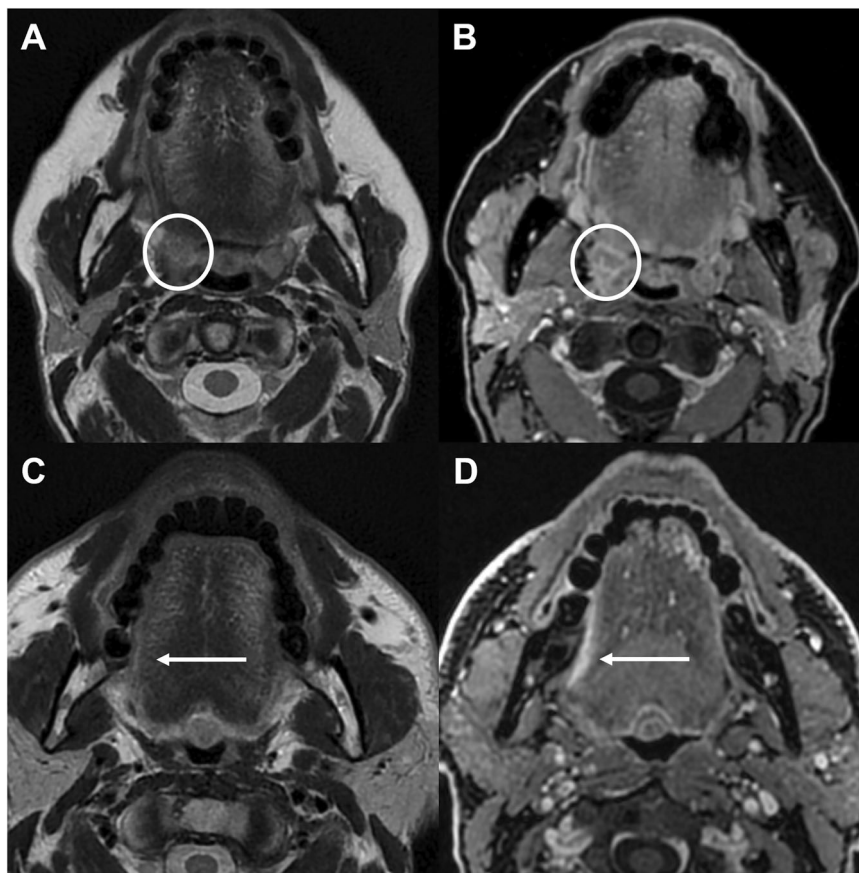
In a patient with a small right tonsillar tumor (circles in A, B) and one with a small right lateral tongue tumor (arrows in C, D), fat-saturated T1-weighted images after GBCAs administration (B, D) better identify the neoplasm compared to T2-weighted images (A, C). GBCA, gadolinium-based contrast agents
